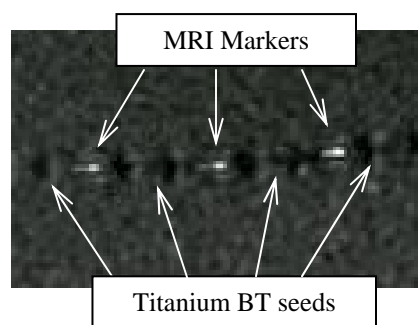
Magnetic resonance image (1.5 T) of brachytherapy strand with integrated MRI markers and BT titanium seeds. MRI markers displayed T<sub>1</sub> positive images.
